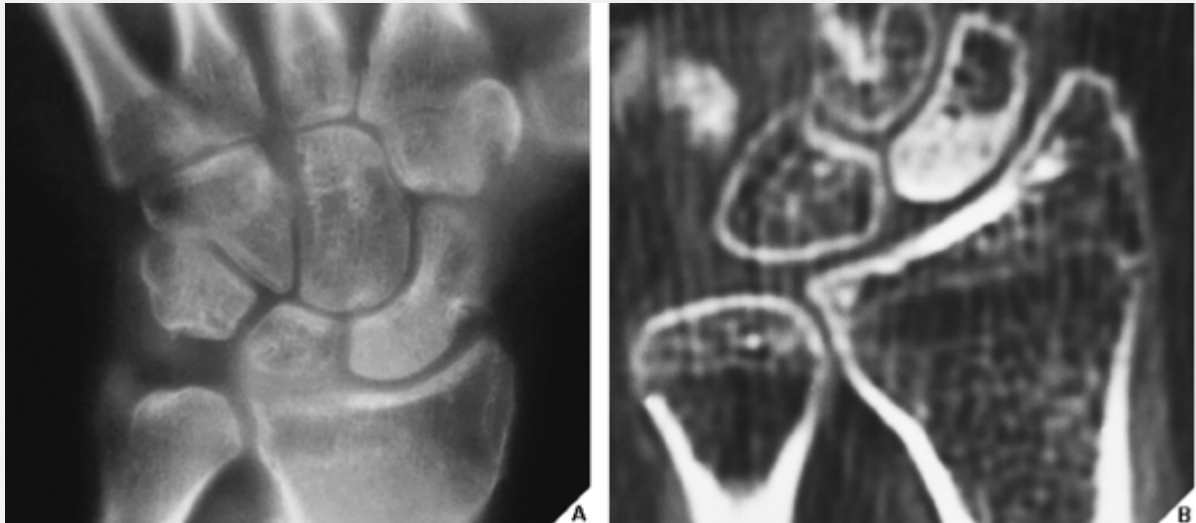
MRI of scaphoid fracture. A 27-year-old man fell on ice and presented with snuffbox tenderness. Dorsovolar (A) in ulnar deviation and oblique (B) radiographs (as well as
